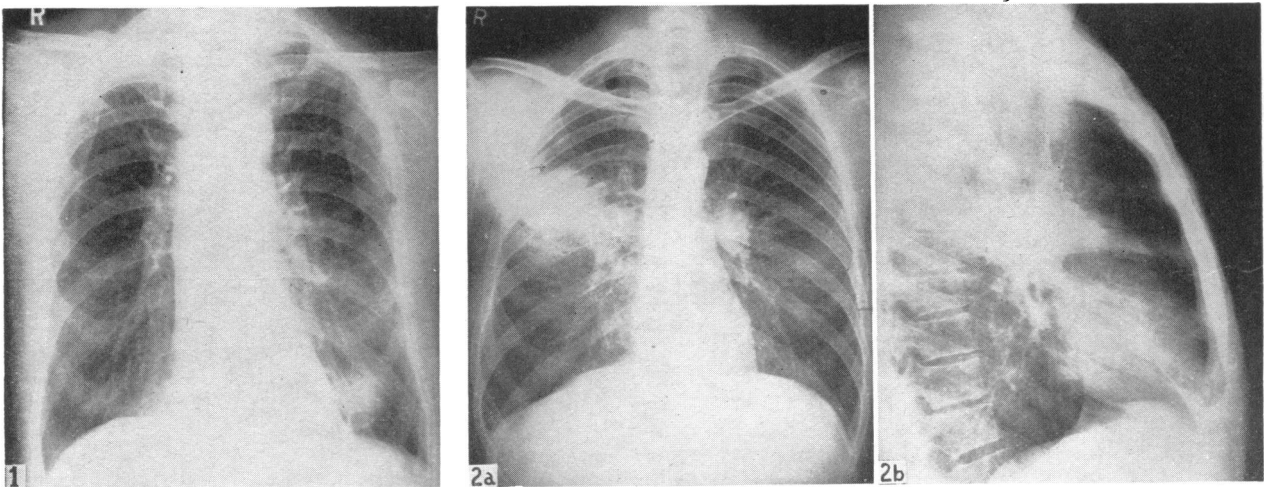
Case 1. Radiograph showing lesion in postero-basilar segment of left lower lobe.
